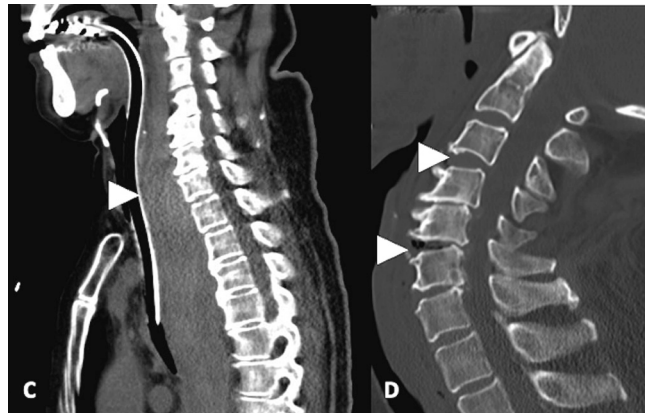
Computed tomography images of Case 2. Arrows denote a massive retropharyngeal hematoma under normal spine position (C), and angular instability between C3/4 and C5/6 under extension view of cervical spine (D).
